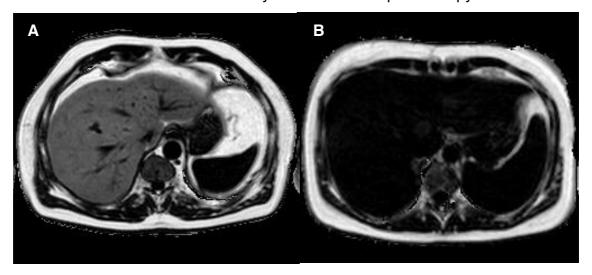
shows two 'fat only' magnetic resonance images of livers. Image A is from a volunteer with hepatic steatosis – approximately 32% liver fat – as indicated by the relative brightness of the liver. Image B is from a control volunteer without hepatic steatosis – approximately 3% liver fat – as indicated by the relative darkness of the liver.
